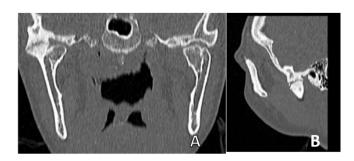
Coronal (A) and sagittal (B) sections of the face CT scan.
